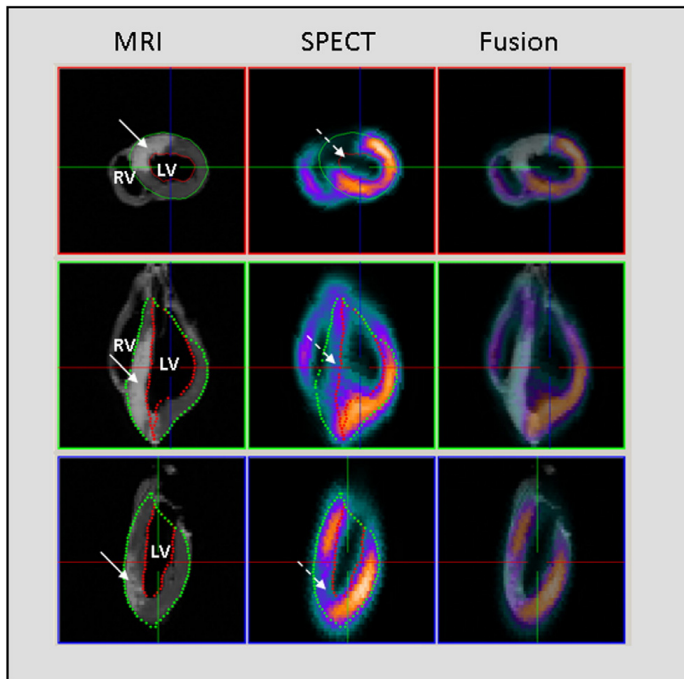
Imaging of MaR and final IS after experimentally induced ischemia by occluding the LAD. Left column, Magnetic resonance imaging performed for visualization of the anterosseptal infarction (solid arrows). Dark gray myocardium indicates viable myocardium and white indicates infarction. Middle column, Single photon emission computed tomography used to assess the MaR by visualization of the anterosseptal perfusion defect (dashed arrows). Warm colors indicate adequate perfusion and cold/absent colors indicate decreased/lack of perfusion. Right column, Fusion of MRI and SPECT images. The upper panel shows a mid-ventricular short-axis slice and the lower 2 panels show 2 long-axis slices. Endocardial and epicardial borders of the left ventricle were manually delineated in the MR images and fused with the co-registered SPECT images. LV indicates left ventricle; RV, right ventricle.
